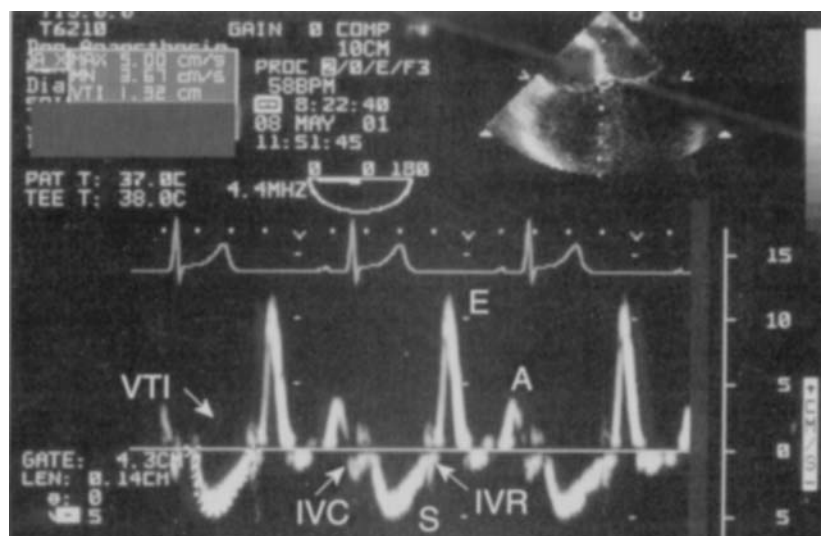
Pulsed wave tissue Doppler recording of mitral annulus velocities in a patient with coronary artery disease. The sampling volume is placed at the junction of the annulus and the interventricular septum, in the mid-oesophageal four chamber view. Velocities of isovolumic contraction (IVC), systolic shortening (S), isovolumic relaxation (IVR), early (E) and late (A) diastolic filling were recorded. Planimetry of the ejection phase of the velocity profile (first beat) gives a peak and mean velocity of 5.0 cm/s and 3.7 cm/s, respectively, and a velocity time integral of 1.32 cm. The latter value equals the displacement of the septal annulus. The early diastolic velocity is distinctly greater than the late diastolic velocity. All of these measurements are within the range of normal values.
